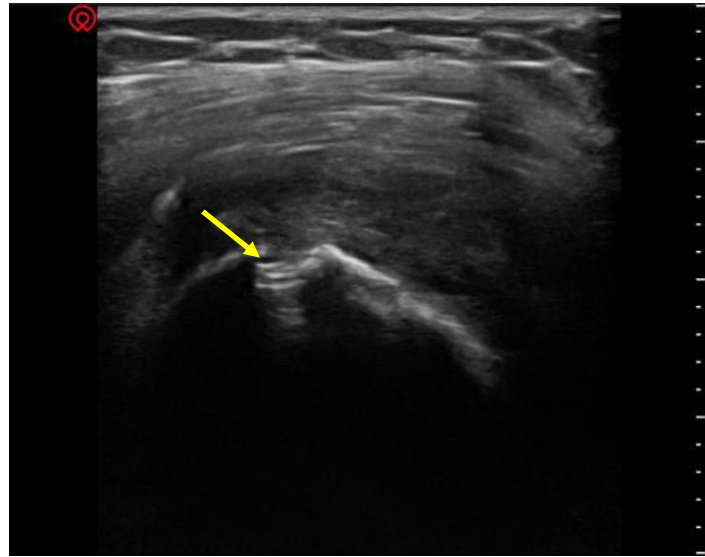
Postoperative follow-up ultrasound of the shoulder of one of our patients, showing continuity of the supraspinatus tendon with visualization of a hyperechoic artifact corresponding to the bioabsorbable anchor at the greater tuberosity. The yellow arrow indicates the bioabsorbable anchor
